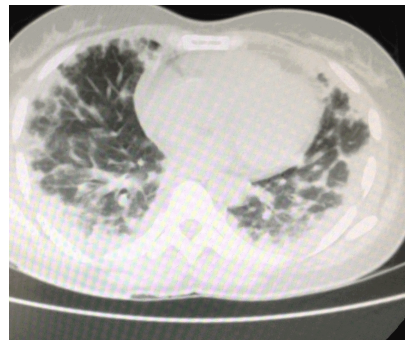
CT Lower lobe Bilateral peripheral based consolidations
